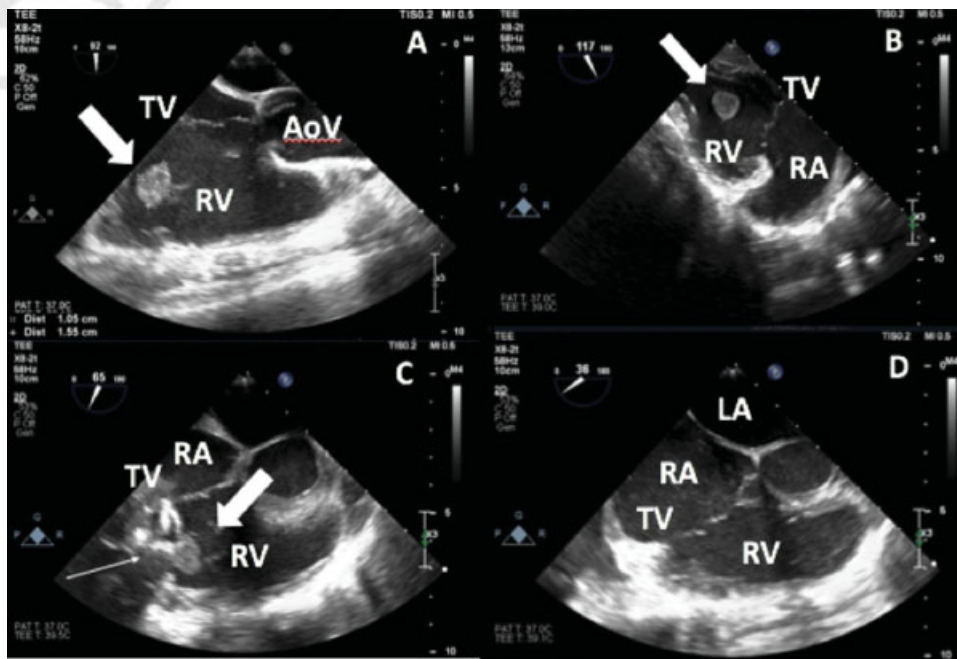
Transesophageal echo images demonstrating (A) short axis and (B) transgastric view demonstrating the mobile mass (thick arrows) attached to the tricuspid valve; (C) a stiff wire (thin arrow) is seen crossing the tricuspid valve for stable positioning of the AngioVac cannulae. (D) Short axis view demonstrating successful extraction of the mass.
